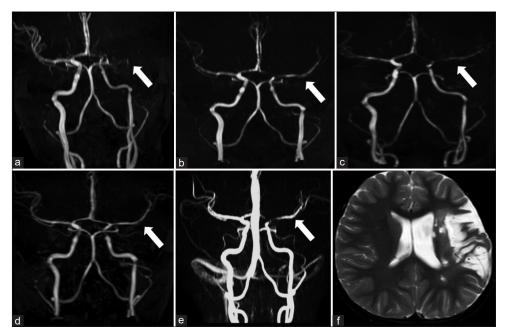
Patient 5: Initial MRA (a) shows the occlusion of the left MCA. Follow-up MRIs at 1 month (b), 6 months (c), 12 months (d), and 24 months (e) demonstrate the patency of the left MCA with minimal irregularity, and these indicate reversibility. On follow-up MRI after 2 years (f), T2WI shows the chronic infarction in the left temporoparietal lobe and also in the basal ganglia and external capsule
